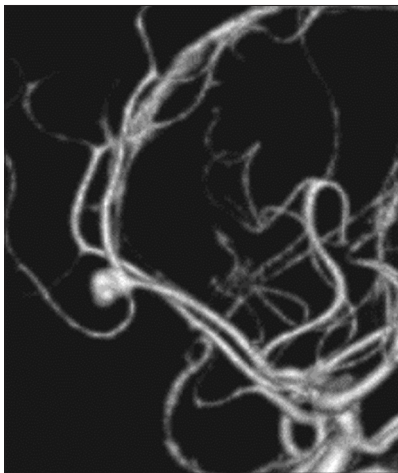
Three-dimensional computed tomography angiography performed at the initial diagnosis showing no vessel stenosis around the aneurysm
